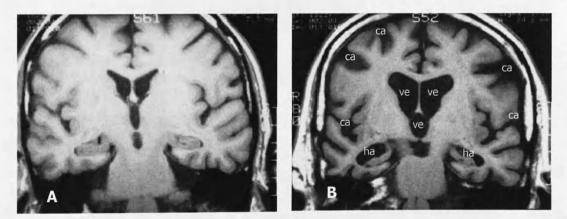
Magnetic Resonance Image of Alzheimer Diseased Brain
